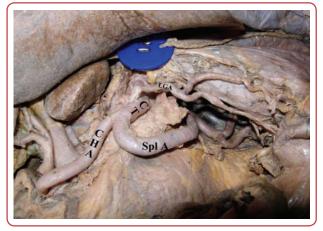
Left gastric artery (LGA) is divided into two branches that supply the anterior and posterior surfaces of the stomach CT = Coeliac trunk; CHA = Common hepatic artery; Spl A = Splenic artery; LGA = Left gastric artery;
